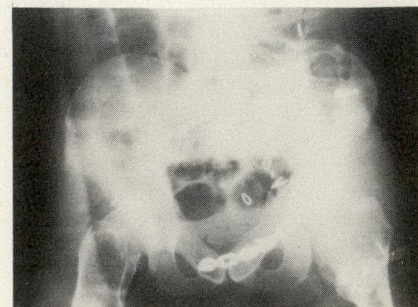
Postoperative roentgenogram of transplanted allograft rigidly fixed with cancellous bone screws posteriorly and pelvic plate and screws anteriorly.
